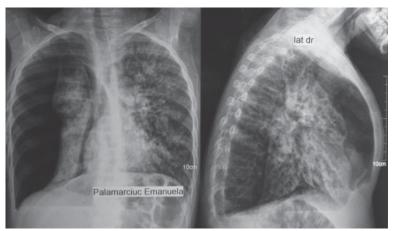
Pulmonary radiography - pneumothorax, the presence of free air in the pleural cavity, the right lung collapsed, the movement of the mediastinum to the left. Deceased child, 9 years, with CF, with Ps. aeruginosa chronic pulmonary infection, F508del/F508del genotype
